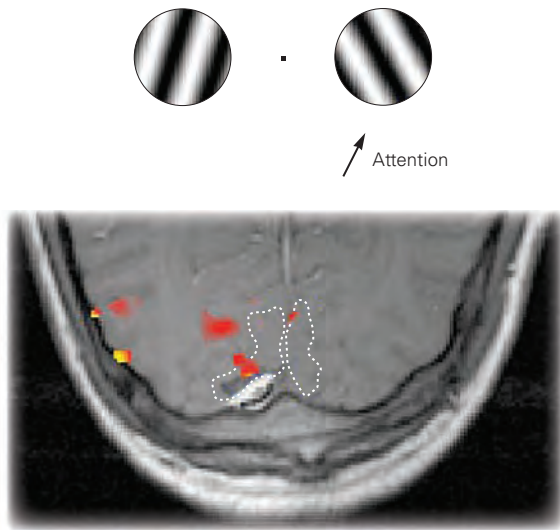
Attention to a visual stimulus alters responses of neurons in visual cortical areas. When we pay attention to a stimulus, we select certain sensory inputs for cognitive processing and ignore or suppress other information. Functional MRI is used in this study to measure the effects of attention to visual stimuli on neural responses in human primary visual (V1) cortex (white dashed lines on the brain anatomical section, lower panel). Moving grating stimuli (upper panel) were presented simultaneously to the right and left visual fields while subjects stared at a central fixation point (black dot). The subjects performed a motion discrimination task, attending (without moving their eyes) to one of the two oriented gratings. When stimuli were attended in the right visual field, neural activity (red) increased significantly in the left hemisphere, but not in the right hemisphere, even though the stimuli were presented to both eyes. When the subject attended to the grating in the left visual field, a similar focus of activity occurred in the right V1 cortex, and activity dropped in the left hemisphere (not shown). (Adapted from Gandhi, Heeger, and Boynton, 1999.)
